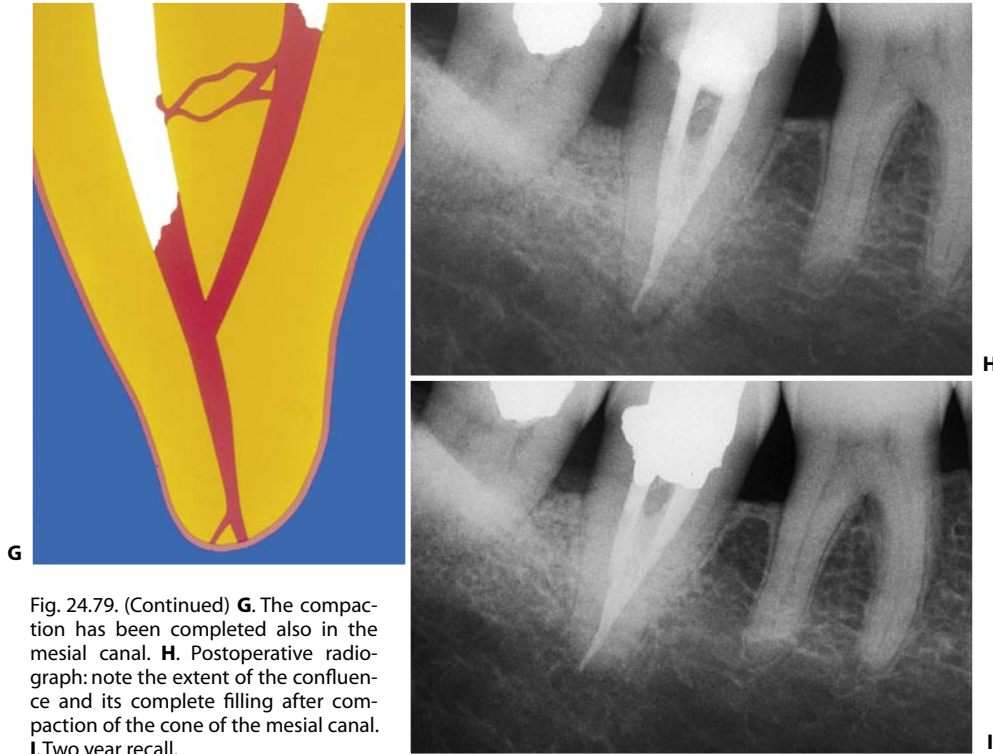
(Continued) G. The compaction has been completed also in the mesial canal. H. Postoperative radiograph: note the extent of the confluence and its complete filling after compaction of the cone of the mesial canal. I. Two year recall.
